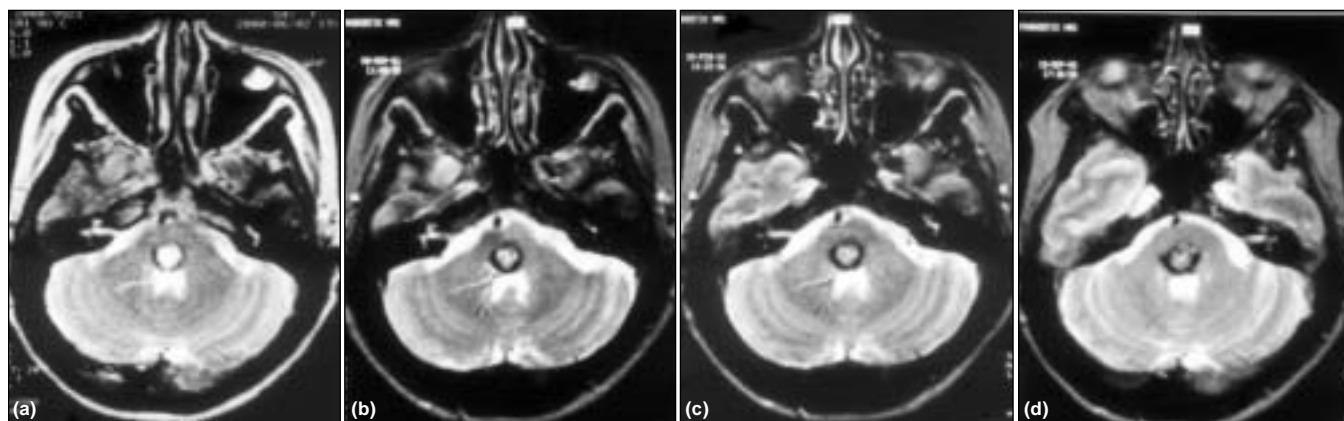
(a) T2 weighted axial MRI of a cavernous angioma is located brainstem. Before SRS (b) 6th month after SRS (c) 9th month after SRS (d) 16th month after SRS. There is no edema around the lesion, no increase in size of the lesion and there is no bleeding after radiosurgery
